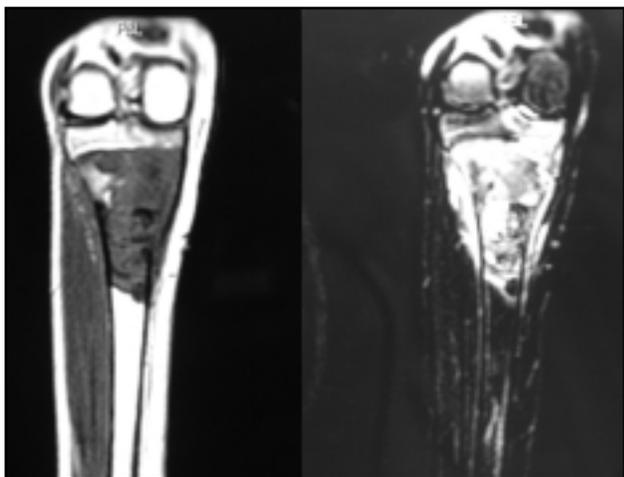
Coronal T1- and T2-weighted images reveal the metaphyseal osteosarcoma with extension beyond the cortices into the soft-tissues as well as into the proximal tibial epiphysis.
